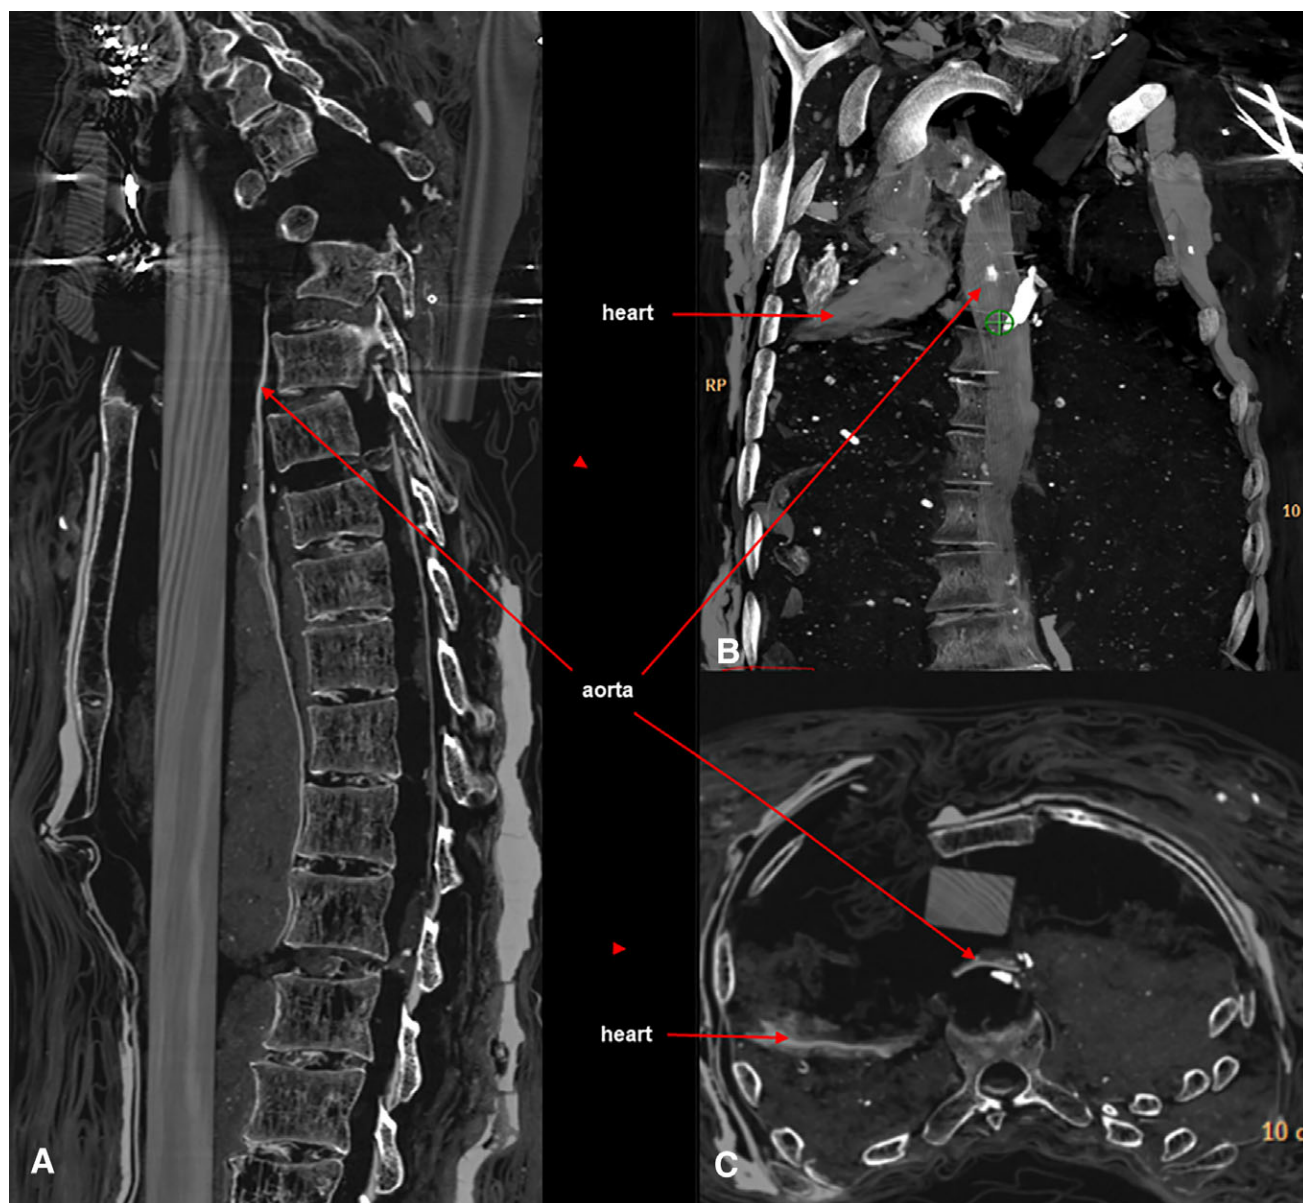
Heart and aorta CT scan. (A) Sagittal view of mummified body and of aorta (red arrow). (B) Maximal intensity projection reconstruction of the aorta and the heart (red arrows). (C) Axial native view of the aorta and the heart (red arrows).
